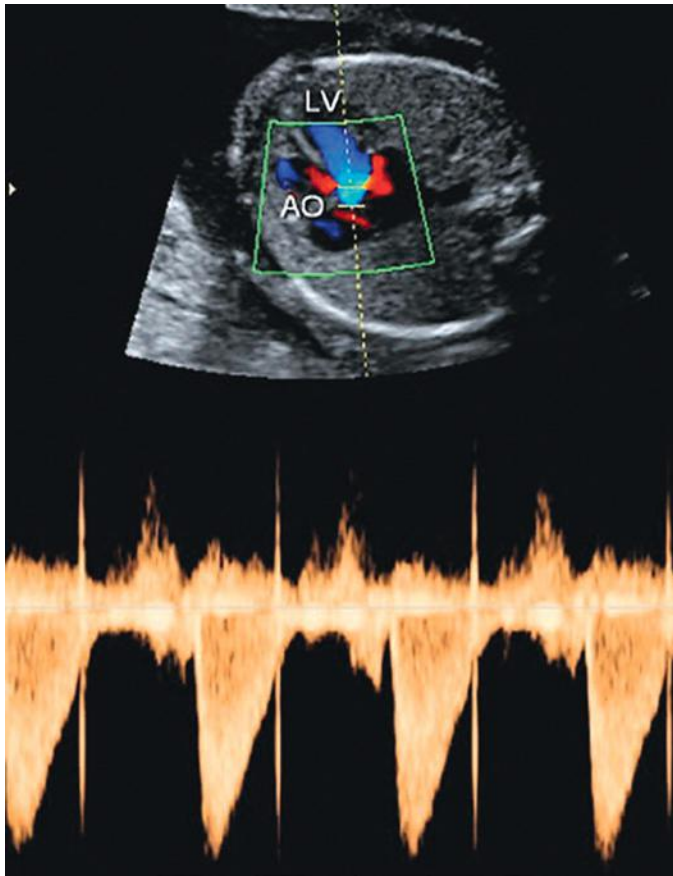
Doppler waveforms obtained across the aortic valve. AO, aorta; LV, left ventricle.
